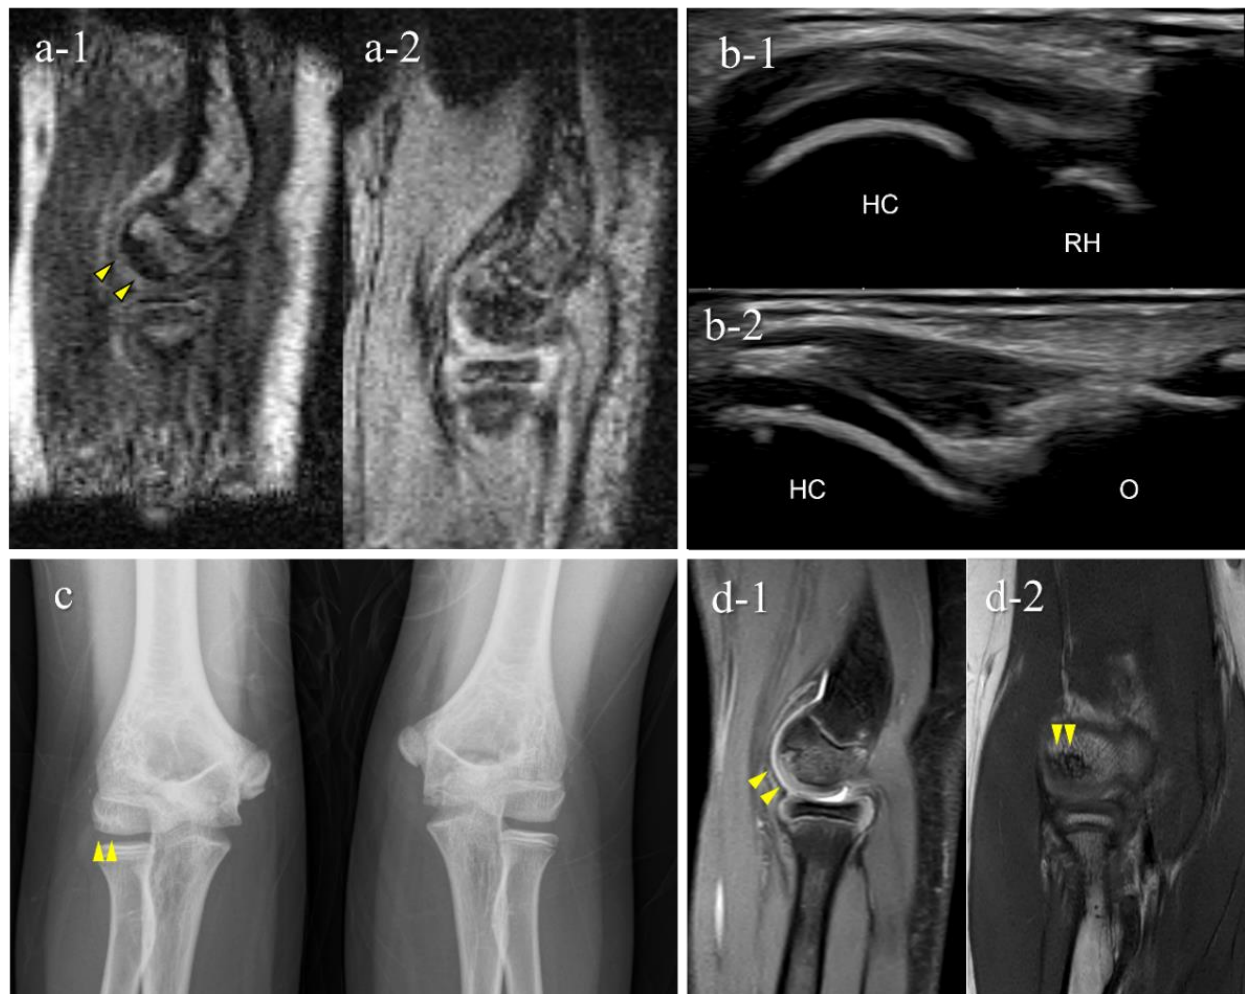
A very early stage of an OCD case (Case 7): Mobile MRI (+), US (−). (a) Mobile MR image of sagittal T1WI: Mobile MRI showing signal intensity changes reflecting bone marrow edema in the anterior humeral capitellum; (b) US image of the posterior longitudinal view: US did not show subchondral bone irregularity; (c) X-p AP view with elbow 45° flexed: X-p 45° showing a translucent area in the central capitellum, stage-I OCD; (d) 3T MR images: d-1, PDWI-FS sagittal image; d-2, PDWI coronal image: localization of the lesion was consistent with that of 3T MRI and mobile MRI.
